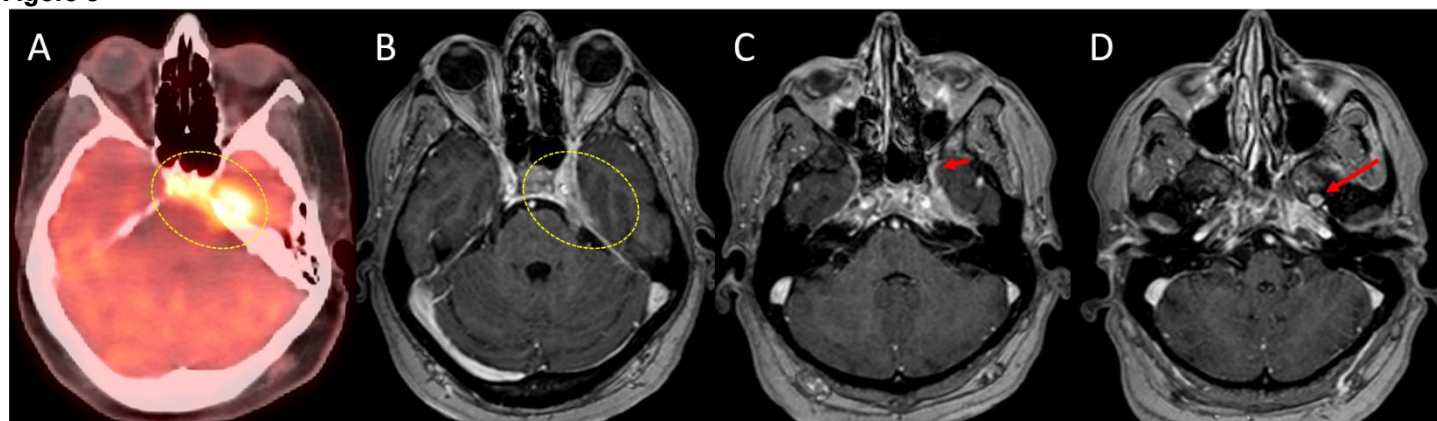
A) Axial PET/CT at the level of skull base shows hypermetabolic lesion involving left petrous apex, dorsum sellae, left cavernous sinus region (dotted ellipse) from lymphoma. B-D) Axial post-contrast MRI shows a corresponding mass-like enhancement in left Meckel's cave region and cisternal segment of left trigeminal nerve (dotted ellipse) also extending along the maxillary division (short arrow) and along mandibular division (long arrow) of left trigeminal nerve consistent with perineural spread.
